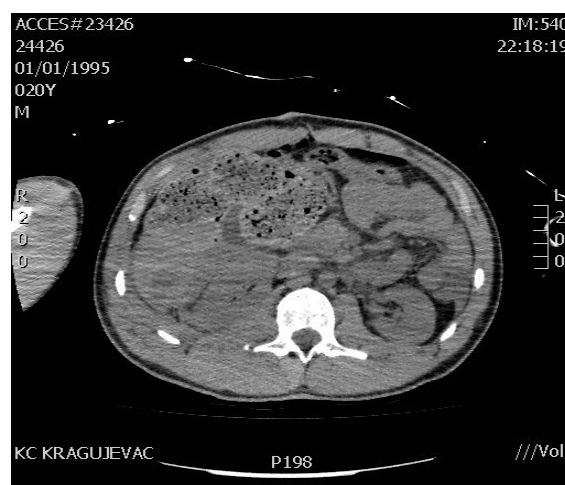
Computed tomography scan image of perihepatic packing after first operation.
